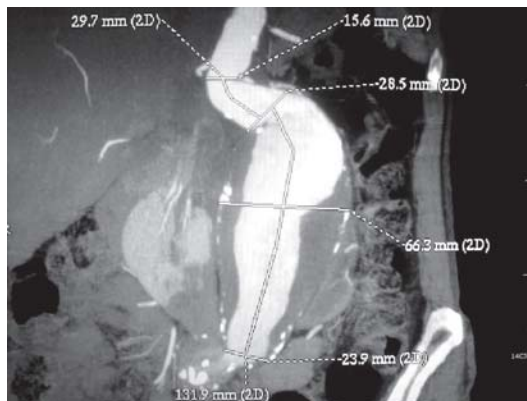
CT with 3D reconstruction demonstrating the AAA with an angulated proximal neck
